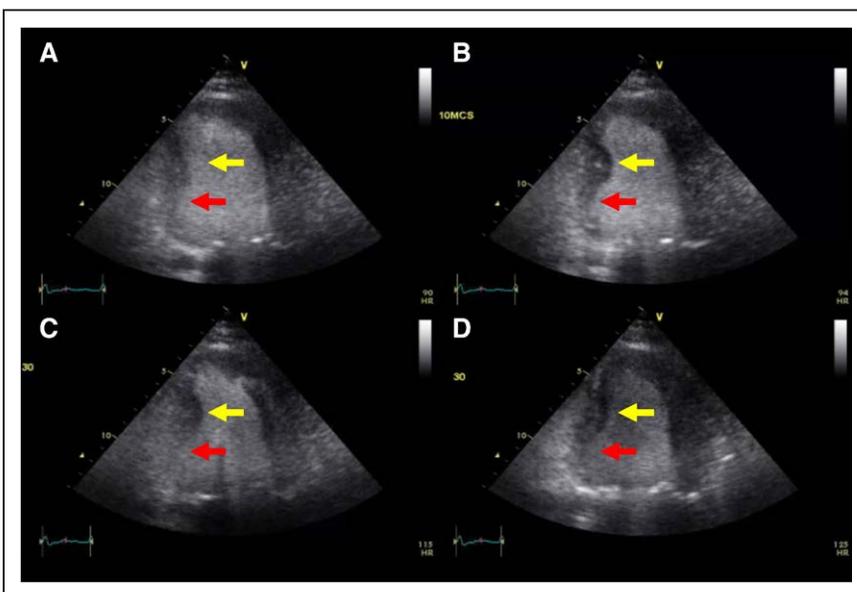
Contrast-enhanced dobutamine echocardiography.
